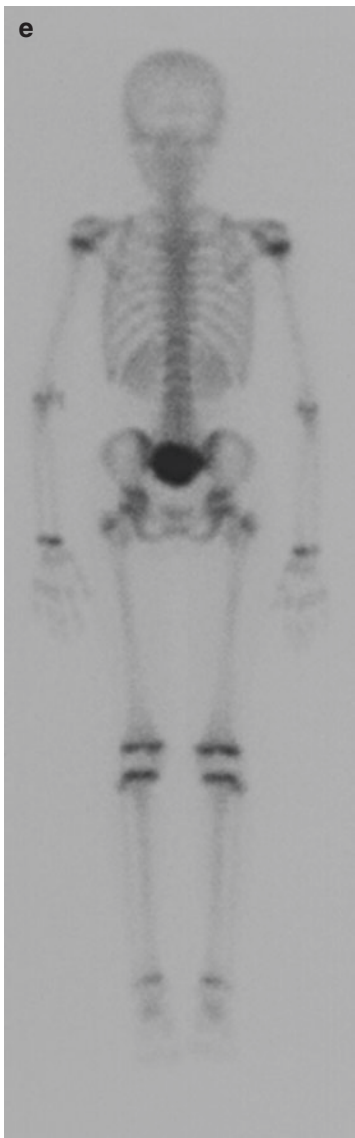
Radiographs obtained in an 11-year-old girl with sacral osteosarcoma. (a) Anteroposterior radiographs demonstrating the amorphous bone density replacing the sacrum. (b) CT scan showed no remnant of normal bone in that region, and amorphous bone production
